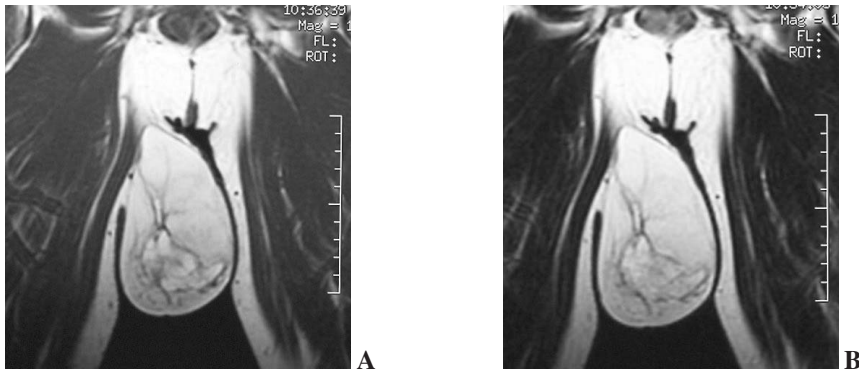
MRI showing a mass with high signal intensities as adipose tissue and irregular septum in the center and distal part of the mass on both T1 (A) and T2-(B) weighted images.
